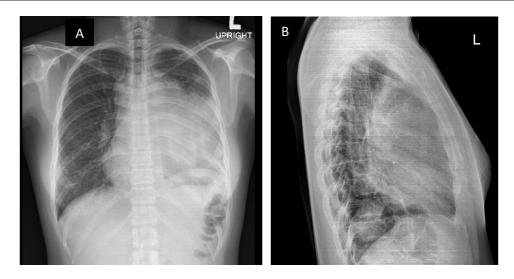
Chest X-ray upright view(A) and lateral view (B) showing haziness in the left lung field obliterating anterior mediastinal cavity.
